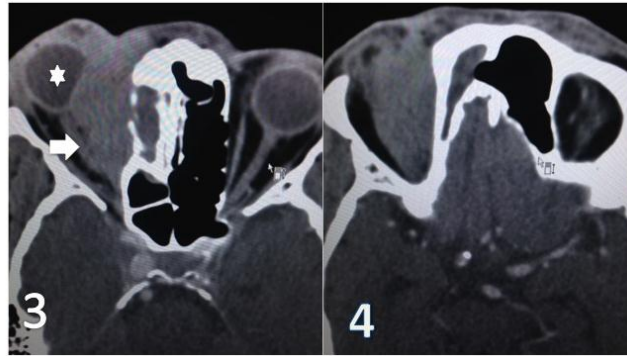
Axial contrast enhanced CT sections shows the moderately enhancing lesion causing compression on the right globe and optic nerve (marked by white block arrow)
